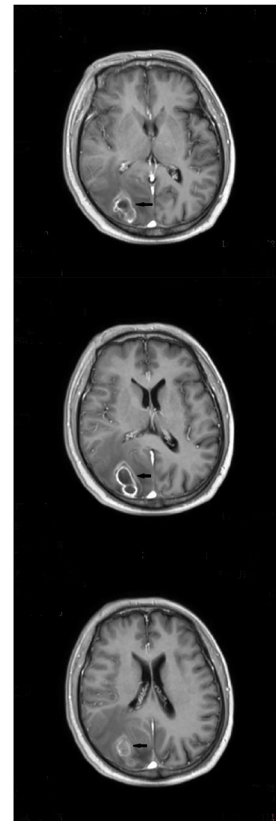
Head magnetic resonance imaging (enhanced T1) of the patient was performed before the operation. The arrow in the picture indicated an intracranial occupying lesion that was considered in the right occipital lobe, but the edema was worse than before, indicating that the disease had progressed.
